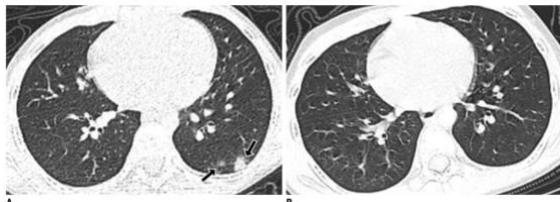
7-year-old twin girl diagnosed with COVID-19. A. CT scan on admission (day 1) showed subpleural ground-glass opacity and consolidation in left lower lobe (arrows). B. On discharge (day 13), acute exudative lesions were substantially resolved after treatment. COVID-19 = coronavirus disease 2019, CT = computed tomography
